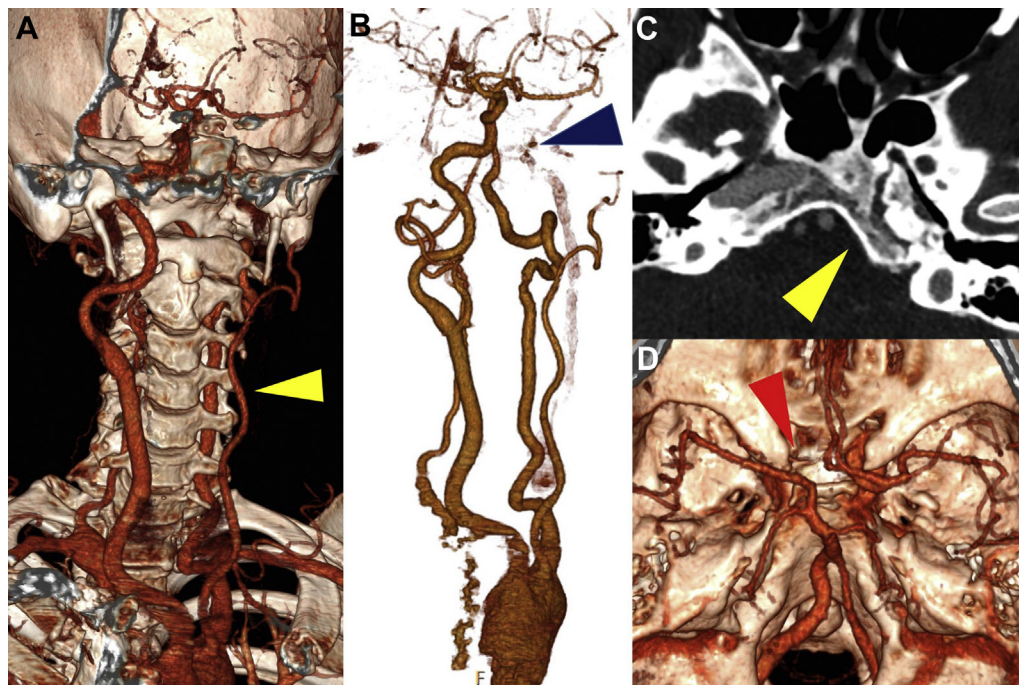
Computed tomography (CT) volume rendering (VR) reconstructions show (A) the hypoplasia of ipsilateral common carotid artery (yellow arrowhead) and (B) the absence of the ipsilateral ICA (blue arrowhead). CT axial image at the level petrous ICA shows (C) the absence of the carotid canal to the skull base (yellow arrowhead). VR reconstructions of the circle of Willis show (D) the type A of collateral pathways cerebral circulation according to the Lie classification and an hypertrophy of vertebrobasilar circulation (red arrowhead). ICA, internal carotid artery.
